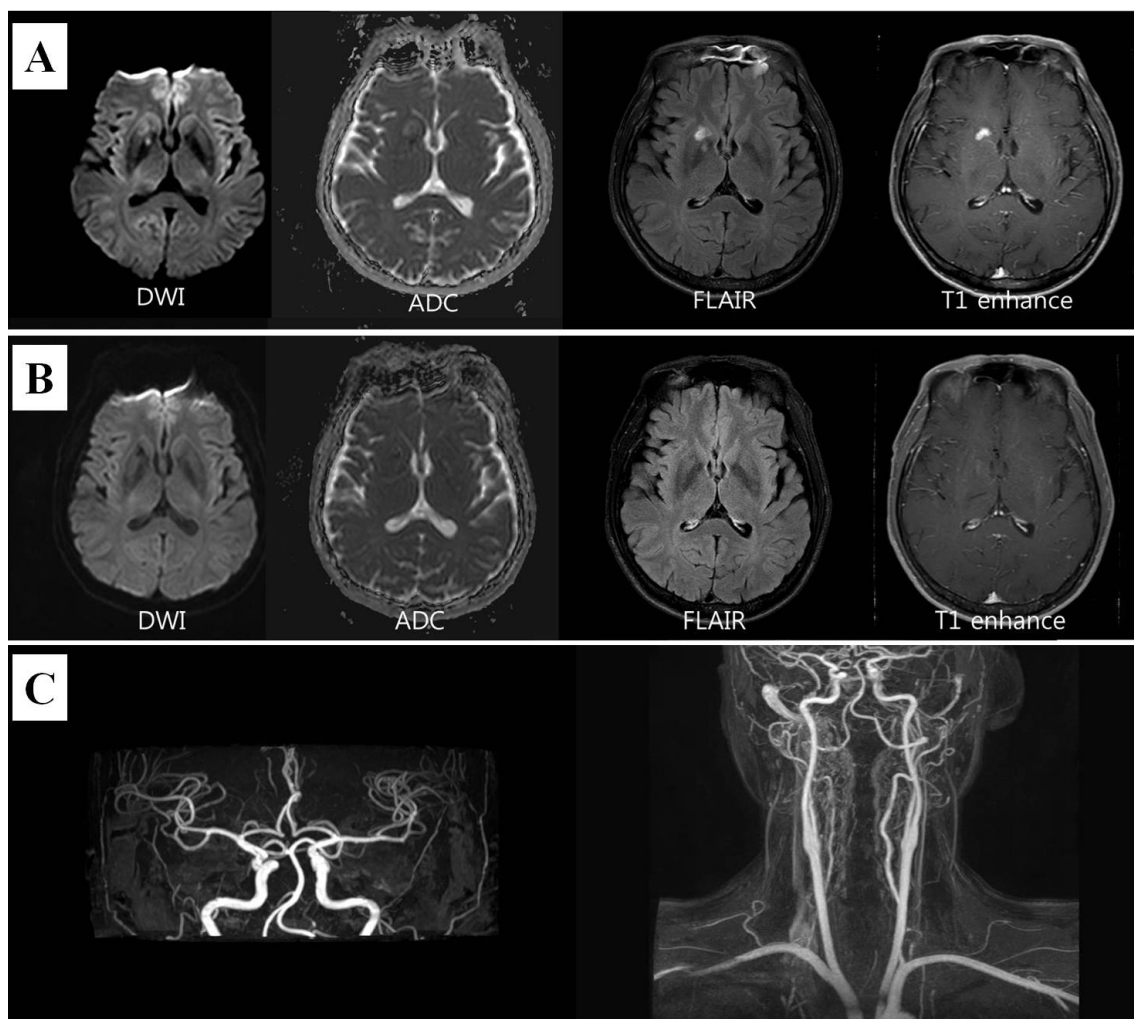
Initial brain magnetic resonance imaging (MRI) using fluid-attenuated inversion recovery and diffusion weighted MRI revealed abnormal high signal-intensity lesion lesions with gadolinium enhancement on T1-weighted MRI in the right caudate nucleus which was consistent with subacute cerebral infarction. This cerebral lesions were diagnosed as vasculitic cerebral infarction caused by eosinophilic granulomatosis with polyangiitis (EGPA) (A). After immune therapy with a high-dose steroid and cyclophosphamide, a follow-up brain MRI showed marked improvement compared to the previous MRI (B). Intracranial MR angiography and neck angiography were normal (C).
